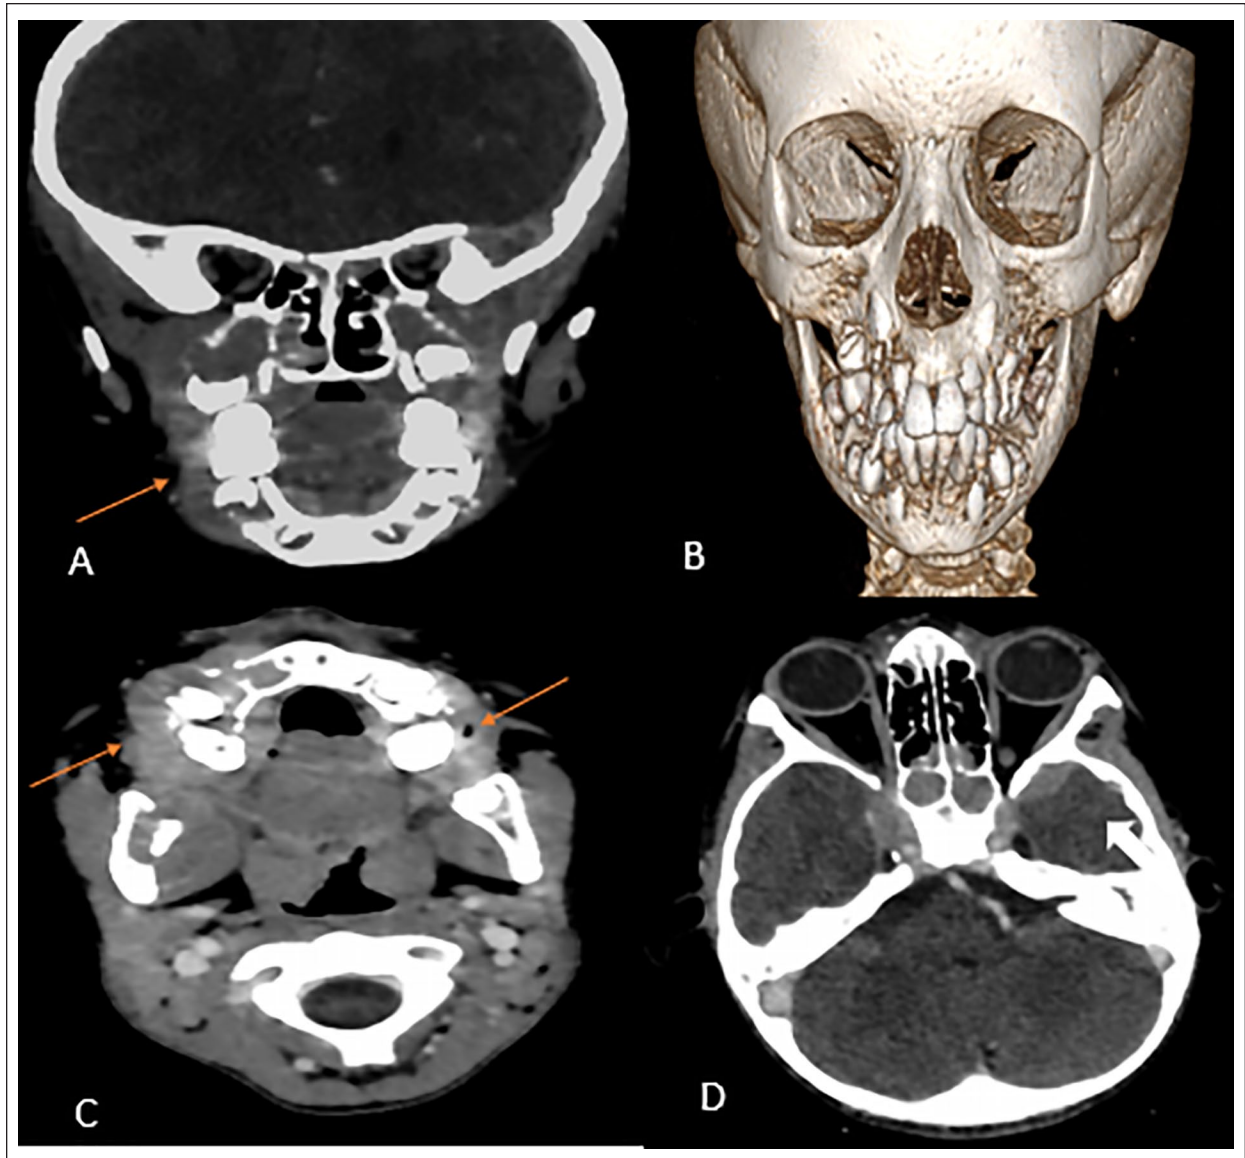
Cerebrofacial CT scan in axial section (C and D) and coronal (A) and 3D reconstruction (B) showing gingival thickening lysing the bone (orange arrow) with tooth displacement and filling the maxillary sinuses, sphenoids with left temporal endocranial extension (White arrow).
